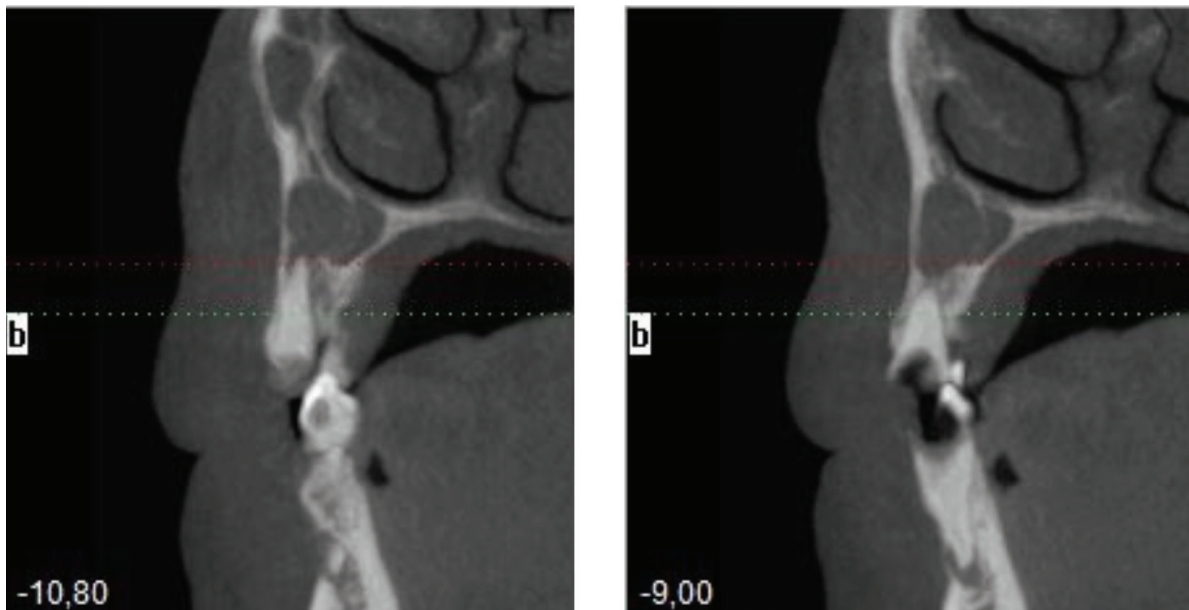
Element 1.2 CBCT frames
